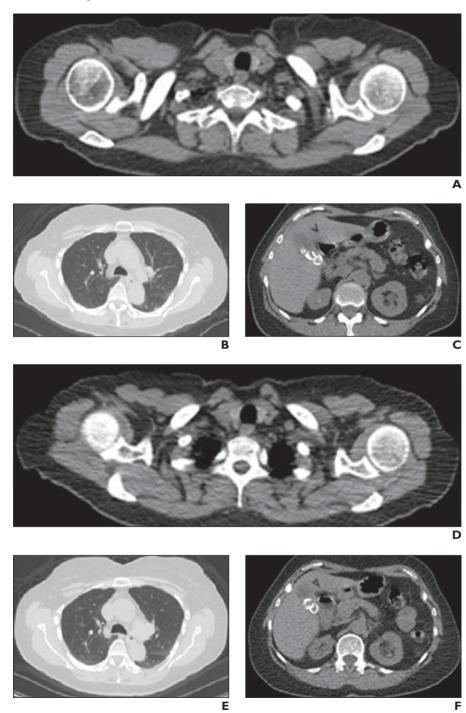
69-year-old woman with body mass index of 24 who underwent scanning before and after CT protocol optimization. Same slice locations in upper thorax, lungs, and abdomen are shown for comparison.
